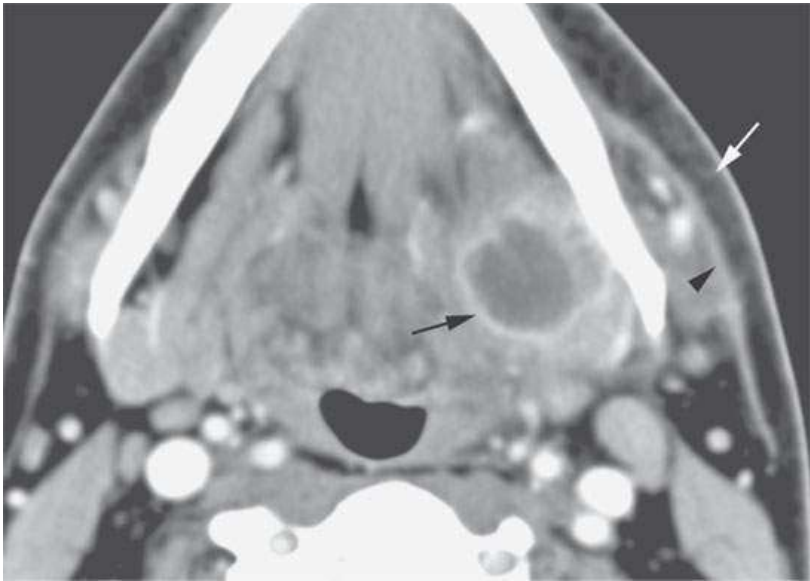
Contrast-enhanced computed tomography of a patient with an acute, untreated abscess of the floor of the mouth and submandibular space with typical features including a thick enhancing rim (*black arrow*), low-density contents, and surrounding cellulitis and edema manifest by thickening of the superficial musculoaponeurotic system (SMAS) layer (*arrowhead*) and subcutaneous edema (*white arrow*).
